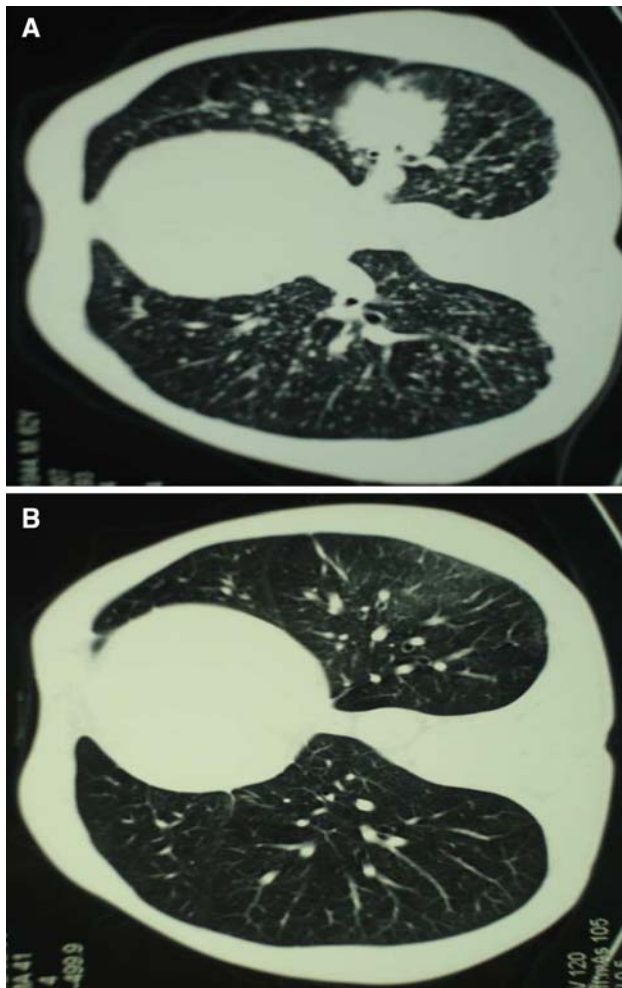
CT scans before (a) and after (b) erlotinib therapy
